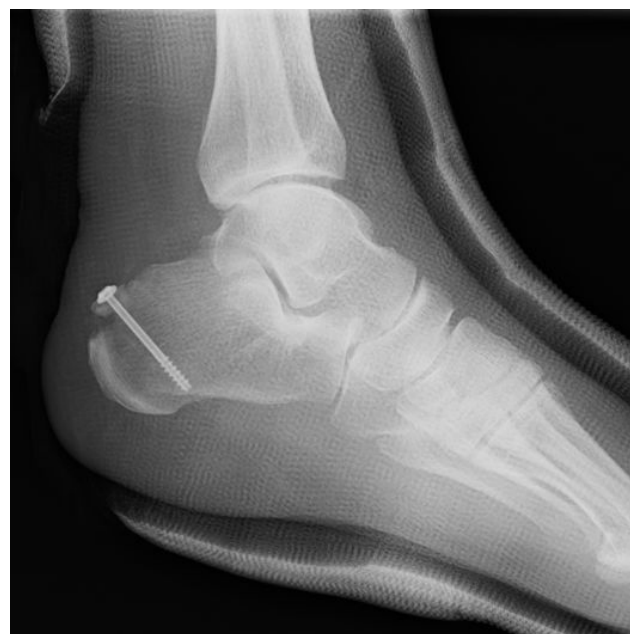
Post-operative plain radiograph.
